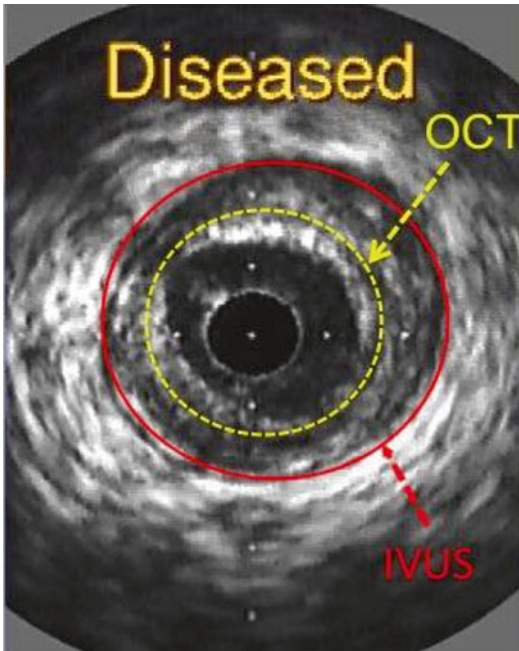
Intravascular ultrasound (IVUS) cross-sectional image of a coronary arterial wall showing the imaging depth obtained by both modalities. *OCT* optical coherence tomography
